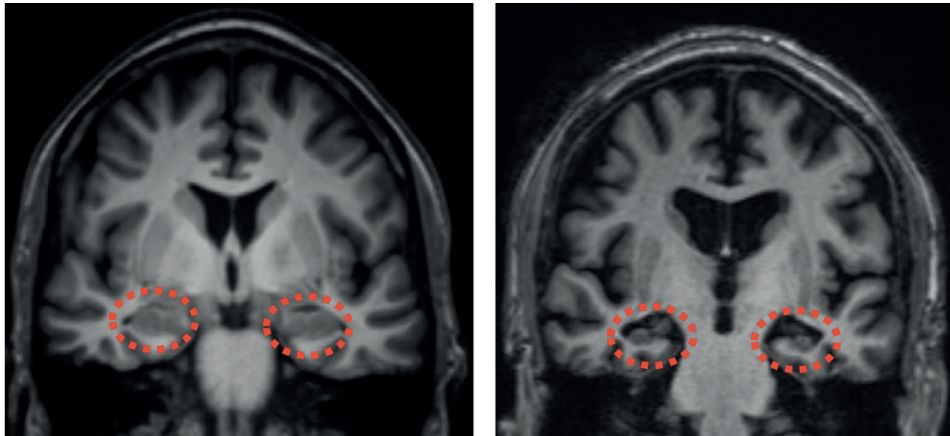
Structural brain MRI scans of a cognitively normal subject (left) and a subject with Alzheimer's disease dementia (right).
